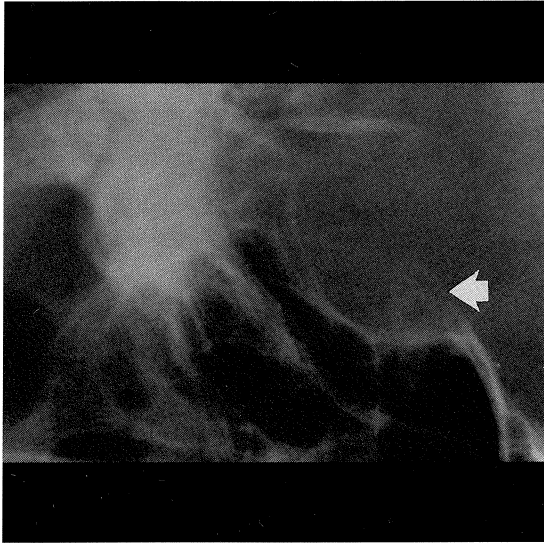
Lateral radiograph of the skull, coned to the pituitary fossa.
